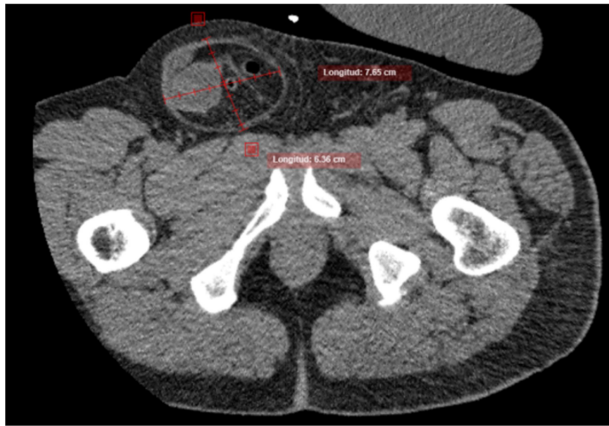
Abdominal CT scan showing a hernial sac measuring 7.6 × 5.3 cm containing intestinal contents.
